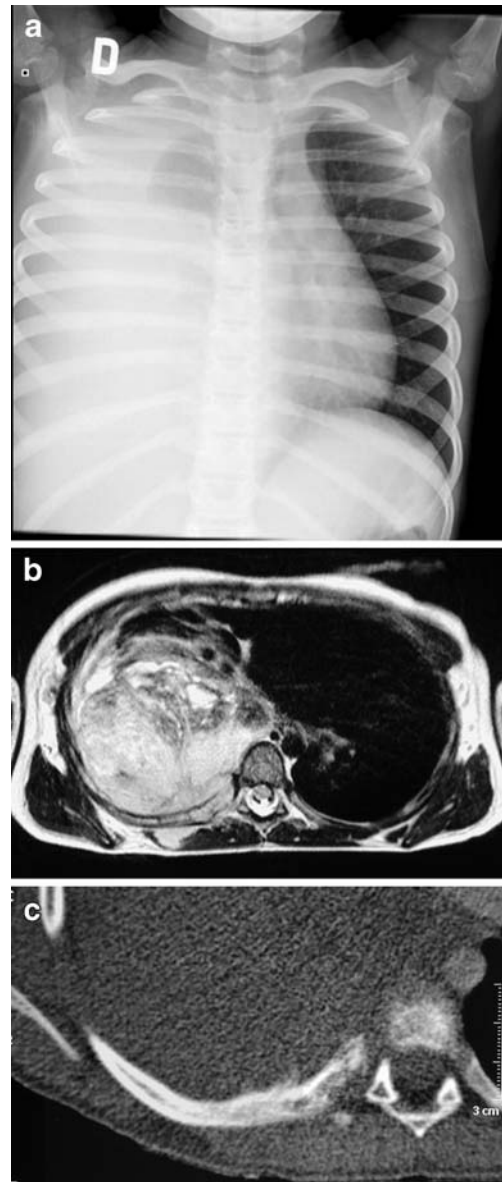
Askin tumor in an 8-year-old girl who was initially diagnosed with right lung pneumonia and pleural fluid. (a) Chest radiograph shows a right lower lobe density and pleural effusion. US of the thorax (not shown) showed a mass in the right thorax. (b) Axial T2-W MR imaging at the level of the mass shows an extrapleural soft-tissue mass originating in the posterior arch of the rib of heterogeneous high signal intensity. (c) A localized low-dose CT slice also shows the bone involvement
